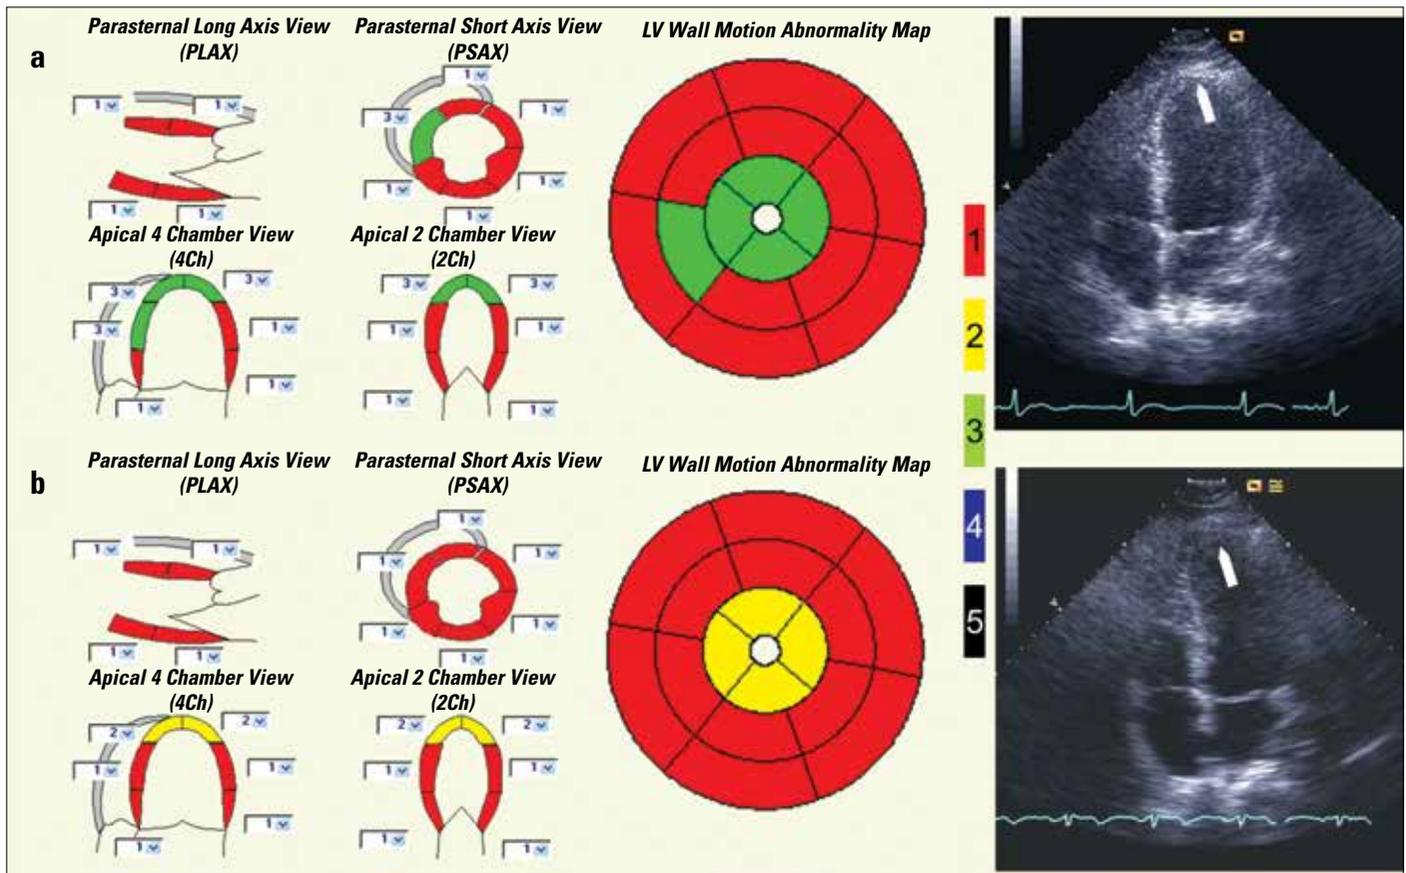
a, b. Wall motion abnormalities detected by echocardiography and registration on polar maps in the HCC software
